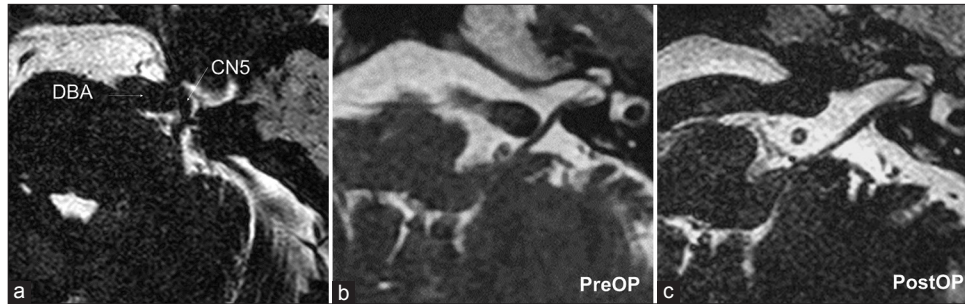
(a) Exclusion of the DVBA to CN5 was released on the postoperative magnetic resonance imaging FIESTA. Changes between (b) preoperative (PreOp) and (c) postoperative (PostOp) in DVBA running at the level of the internal auditory meatus. DVBA: Dolichoectatic basilar artery, CN5: Trigeminal nerve, FIESTA: Fast imaging employing steady-state acquisition.
